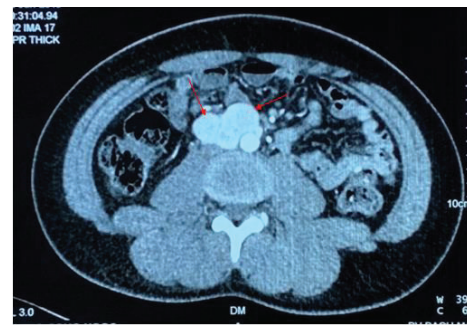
CT scan showed a retroperitoneal tumour in front of the AA, at the level of the inferior mesenteric artery, with 48x28 mm in size, clearly demarcated, hyper-enhancing, with a central necrosis (red arrows).
